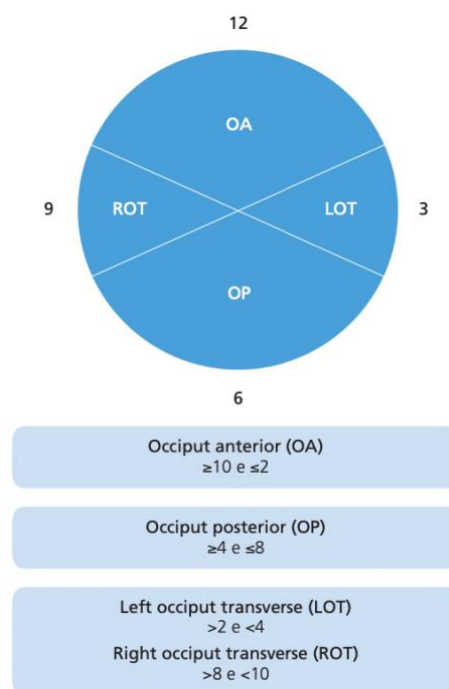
Classification of fetal occiput position (Adapted from *Ultrasound in labor: clinical practice guideline recommendation by the World Association of Perinatal Medicine (WAPM) and the Perinatal Medicine Foundation (PMF)*)¹
